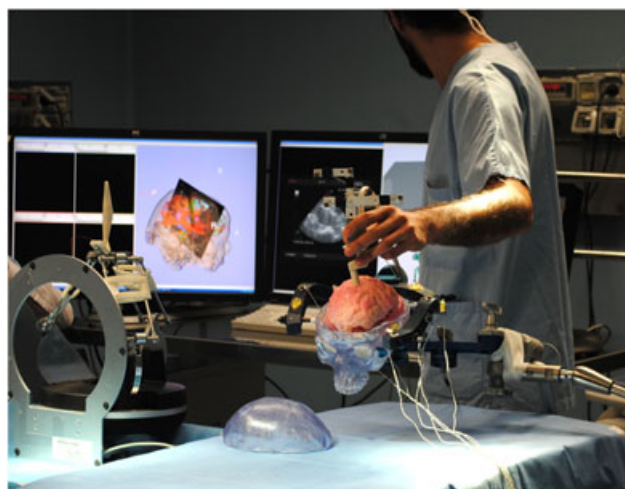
The ROBOCAST demonstrator used in *in vitro* trials at Ospedale Maggiore (Verona, Italy). The operator is manoeuvring an ultrasound (US) probe while looking at the intra-operative visualization monitors. The US image is superimposed on the pre-operative brain models
